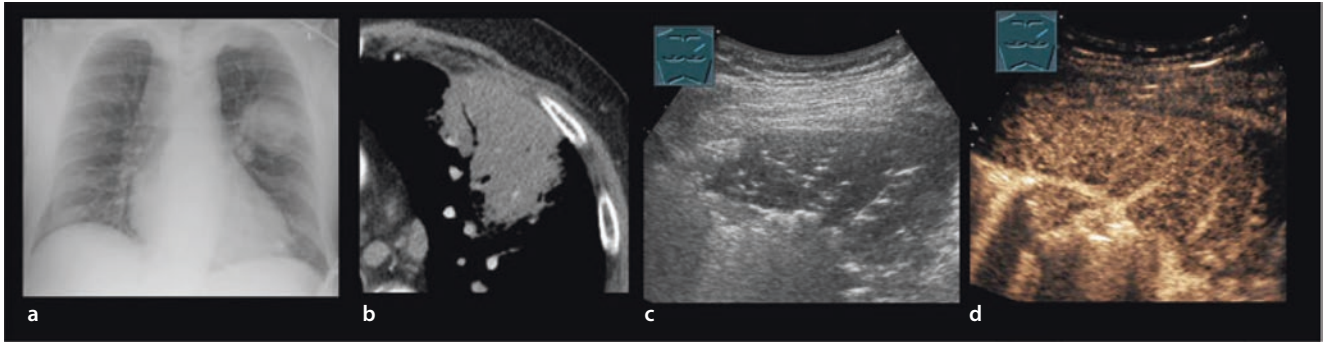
Man with dyspnea, no fever, and a space-occupying lesion in the right middle lobe of the lung, which is seen on the conventional X-ray (a) and on CT (b) as typical pneumonia. c B-mode ultrasound shows a hypoechoic consolidation with an air
